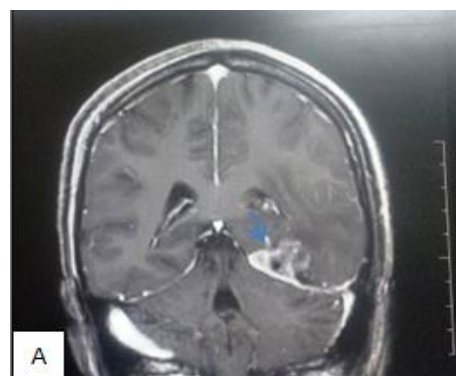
A. MRI shows tumor mass in left frontal lobe with edema (arrow).
